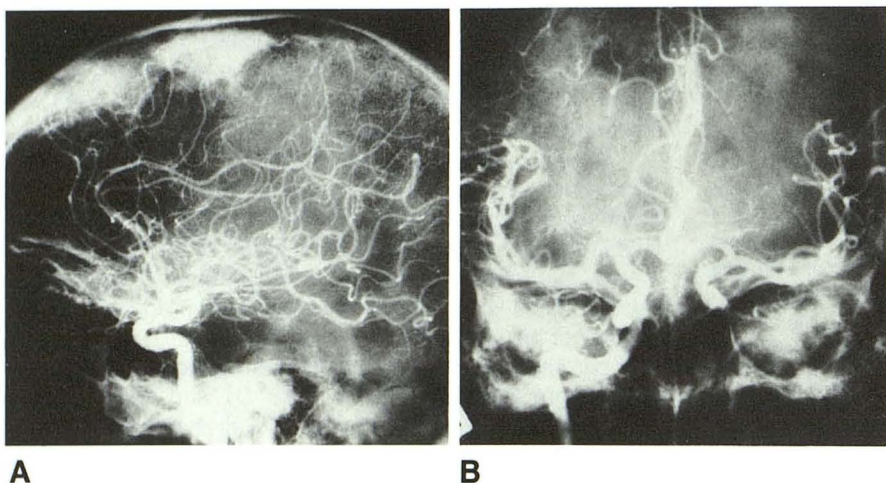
A, and B, Right internal carotid arteriogram. Anteroposterior and lateral views show no neovascularity in region of dense calcification corresponding to the lesion seen on CT. Note dural calcification extending into interhemispheric fissure and involving the falx.
